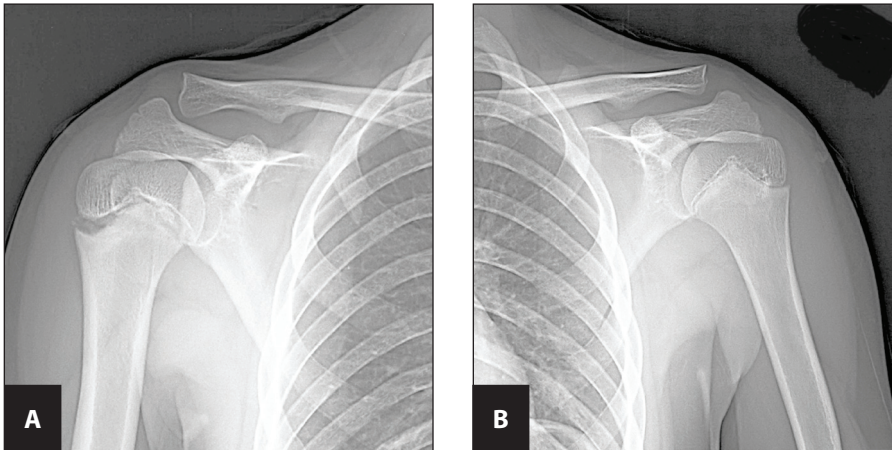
(A) Anteroposterior shoulder radiograph of the affected throwing shoulder. Note the lateral humeral physeal widening. (B) Normal comparison radiograph of the contralateral shoulder.
